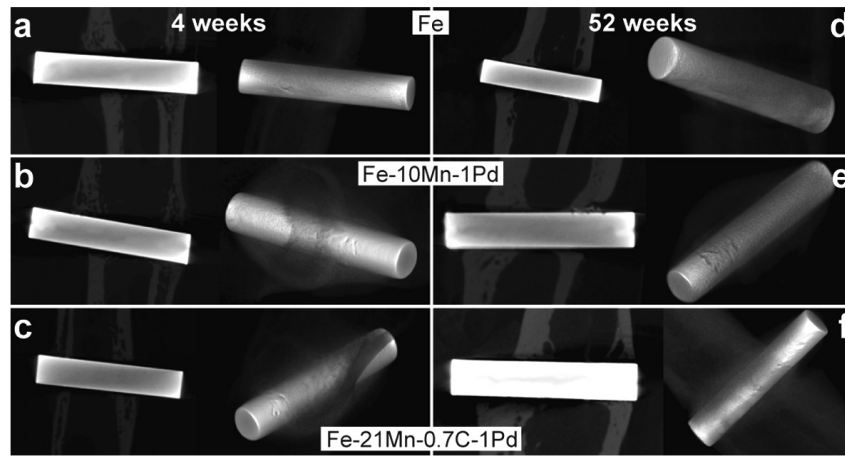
Conducted  $\mu$ CT scans of pure Fe, Fe-10Mn-1Pd and Fe-21Mn-0.7C-1Pd are displayed at the early time point 4W and the late time point of 52W. No evidence for visible degradation was found. Published in Kraus et al [2].
